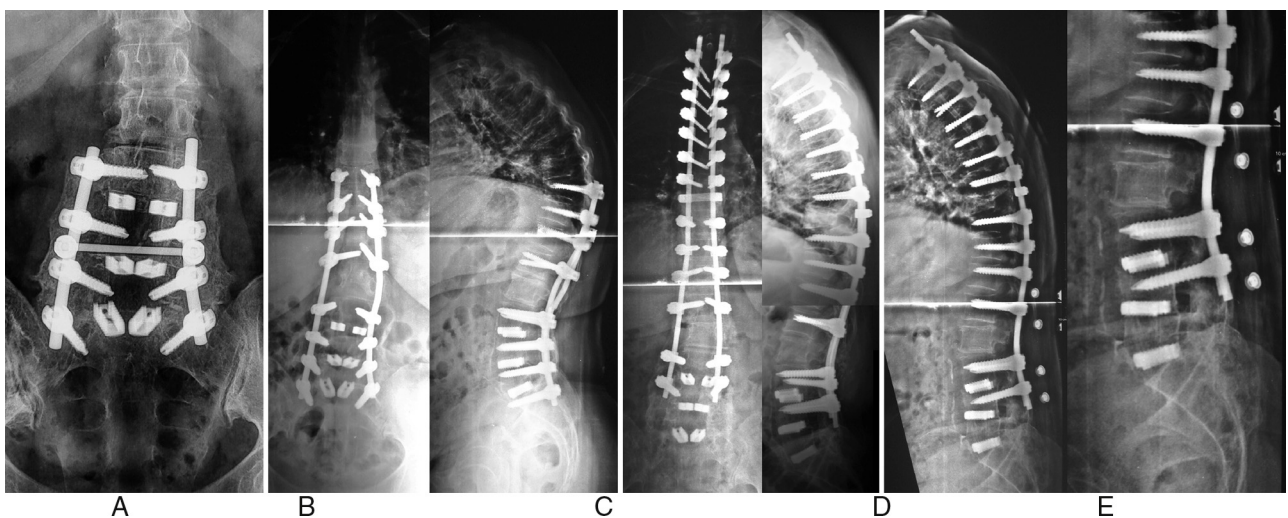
L3-S1 arthrodesis for over ten years, which evolved with L2-L3 stenosis and extension of the fixation up to T10 for three years, developing progressive junctional kyphosis. (A) Radiograph showing the consolidation of the old arthrodesis. (B) Extension of the fixation up to T10, with development of junctional kyphosis. (C) Postoperative radiograph showing fixation extension up to T2 and T9 PSO, with good kyphosis correction. As the lumbar segment was firmly consolidated and there were 12 anchorage points distal to the osteotomy, it was decided to fixate only up to L4. (D) Radiograph 60 days after surgery showing loss of lumbar lordosis and sagittal imbalance. The patient projected her trunk when rising from a low chair and felt a crack in her lower back. (E) Detail of the radiograph showing wedging of L4 and lumbar rectification. As the patient had pulmonary thromboembolism postoperatively and was anticoagulated, in addition to other clinical problems, it was decided to maintain the use of a vest and observe the evolution (case 11).
